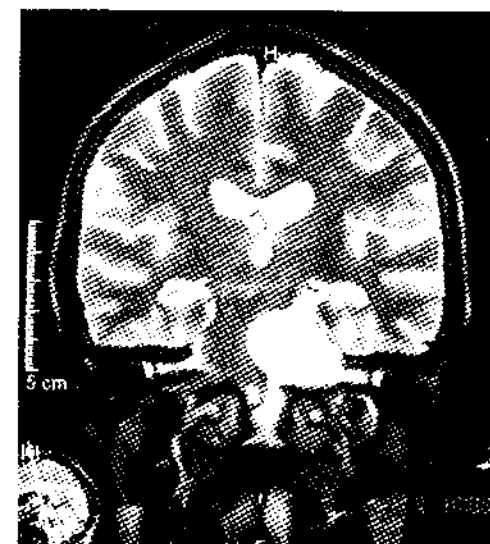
MRI of a patient with left acoustic schwannoma
